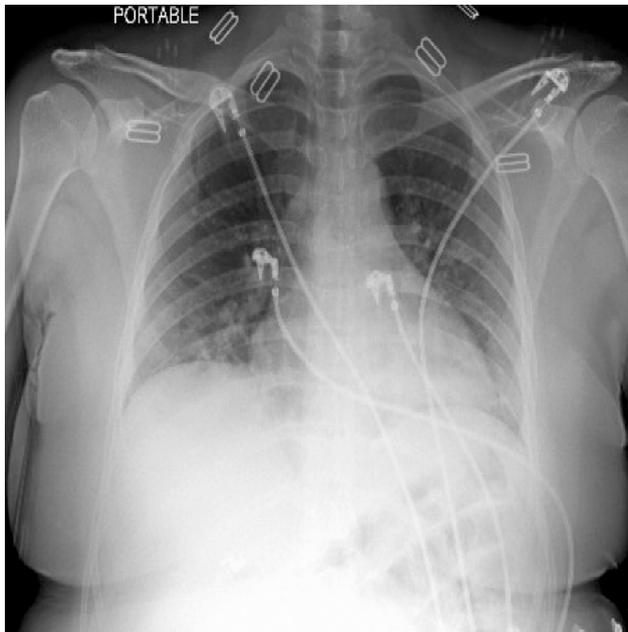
Chest X-ray on representation for second admission. Radiologic impression: patchy airspace opacification in the lower lobes with vascular crowding.
